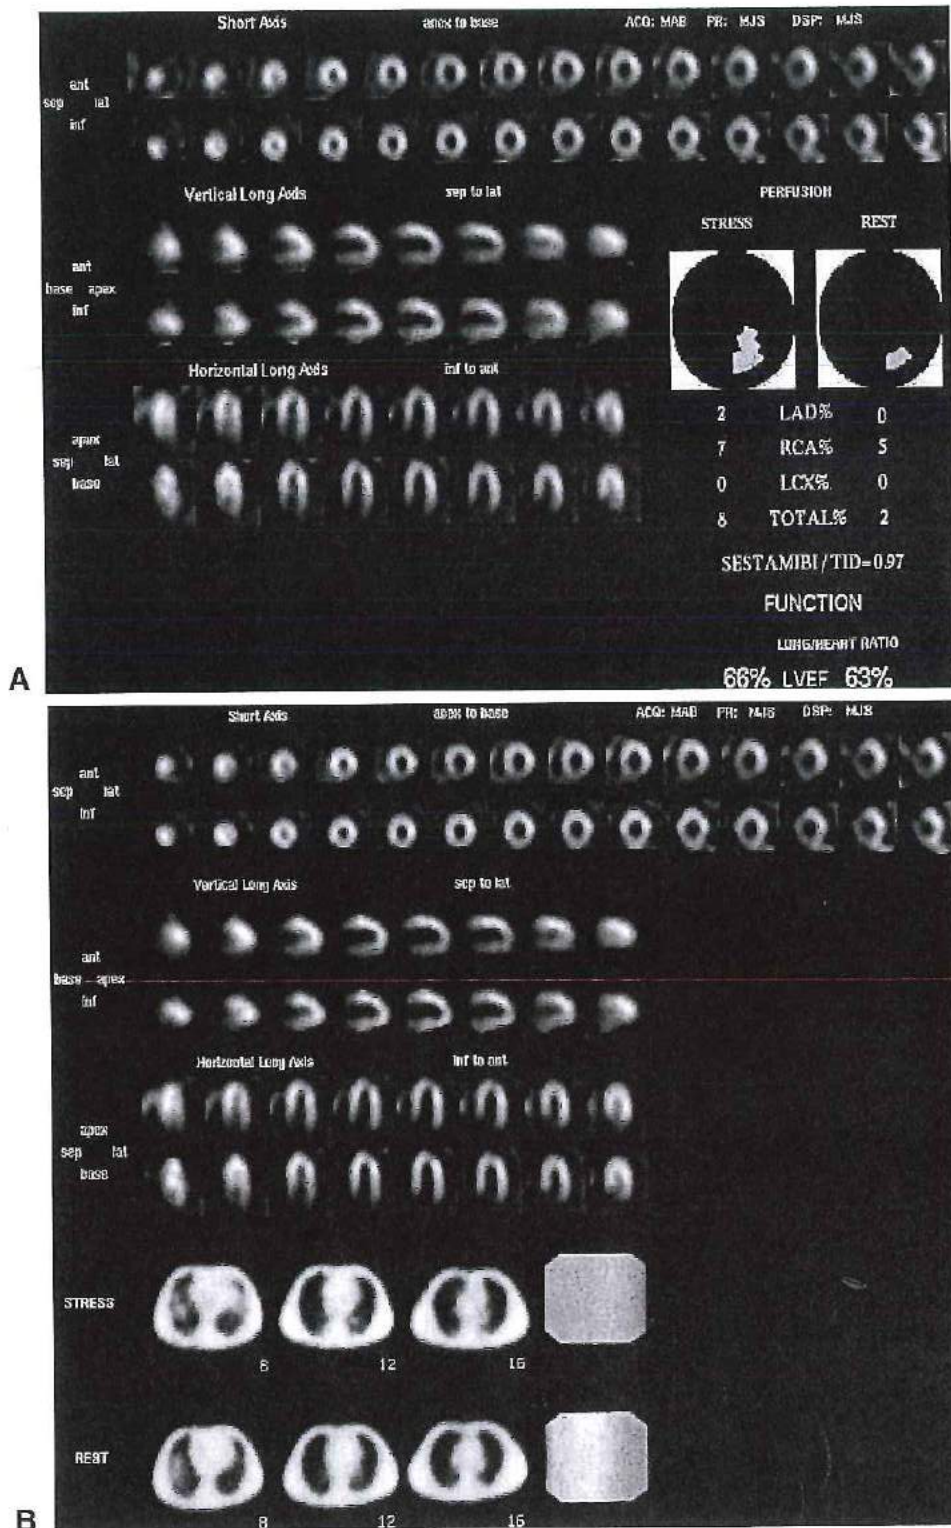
A, Exercise-rest Tc-99m sestamibi SPECT study, suggestive of ischemia in the inferior, inferolateral, and inferoseptal regions but confounded by the presence of possible subdiaphragmatic attenuation. B, After attenuation correction, the SPECT study demonstrates definite ischemia in the distribution of the right coronary artery. Attenuation map samples and daily reference scans are shown for quality control.
